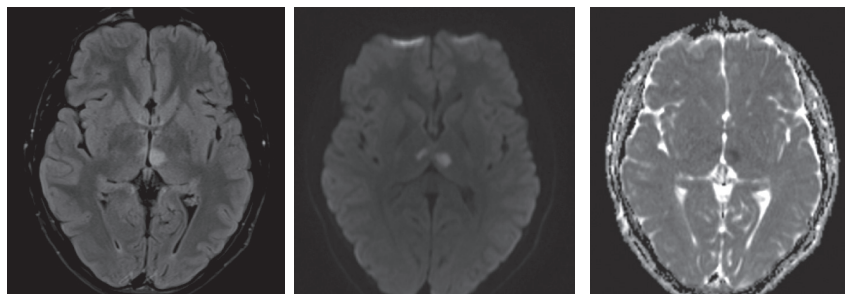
T2W/FLAIR (A) and DWI (B) lesions corresponding with ADC map (C) in medial parts of the thalami 24 hours after the onset of symptoms depicting a characteristic pattern of ischemia caused by the occlusion of Percheron's artery.
